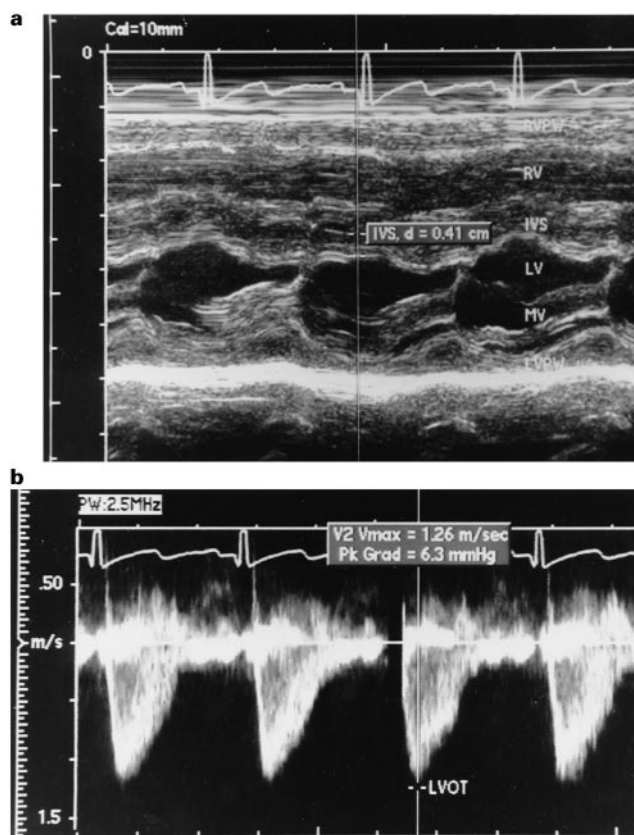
(a) A post-transplant M-mode echocardiography 4.5 months after stopping the steroid therapy, showing complete normalization of the dimensions of the ventricular cavities and wall thickness of the free ventricular walls and the septum. The systolic anterior motion of the mitral valve has resolved. (b) The dynamic pressure gradient across the left ventricular outflow tract has resolved (normal ≤ 10 mmHg for age). Abbreviations as in Figures 1 and 2.
